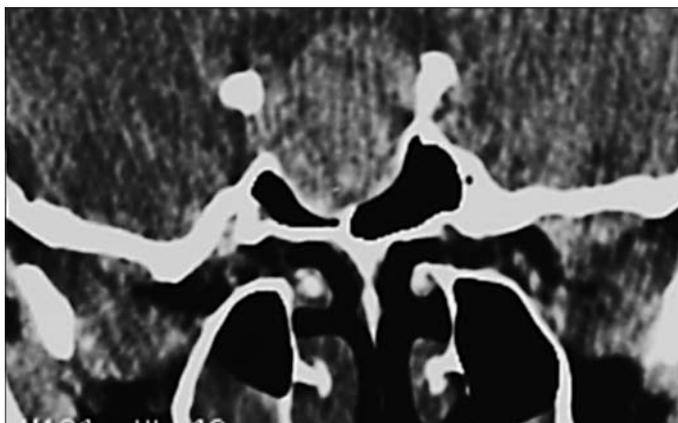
Preoperative CT scan. On coronal image, there is a 2x2 cm mass, with widening and cortical destruction at the sella
